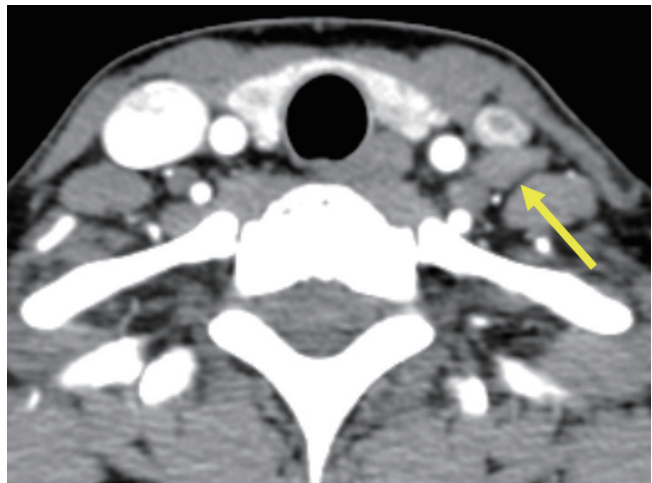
Axial computed tomography scan shows a lymph node without a hilar structure, internal cystic changes, heterogeneous enhancement, calcification, or strong enhancement (arrow). This lymph node would be classified into an indeterminate category according to K-TIRADS. K-TIRADS = Korean Thyroid Imaging Reporting and Data System
